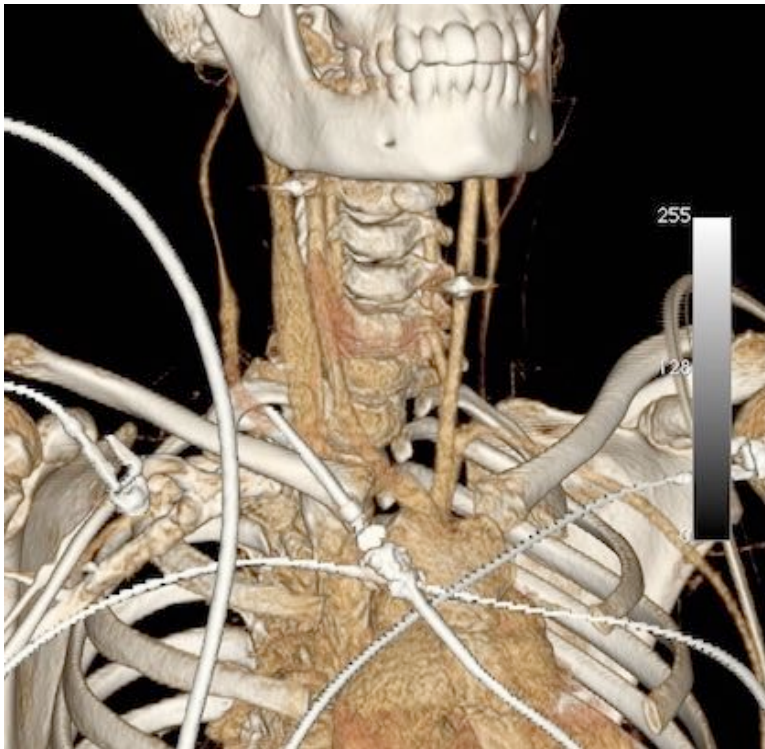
Three- dimensional reconstruction of a CT angiogram demonstrating energised fragments lying in close proximity to the common carotid and external carotid arteries.
